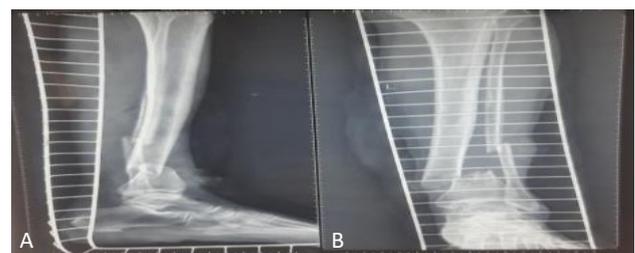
(A and B): Pre-operative radiograph.
